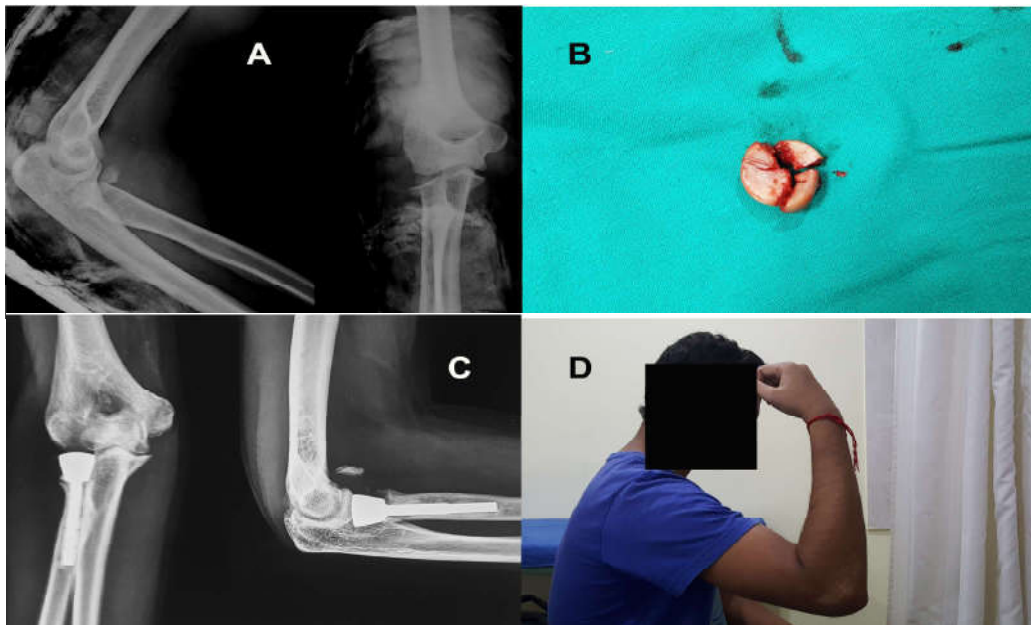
A, Mason type III fracture of the right radial head; B, Excised fragments of the radial head; C, Follow-up radiograph of the elbow showing the prosthesis in place; D, Flexion achieved in the operated elbow after two years follow-up.
